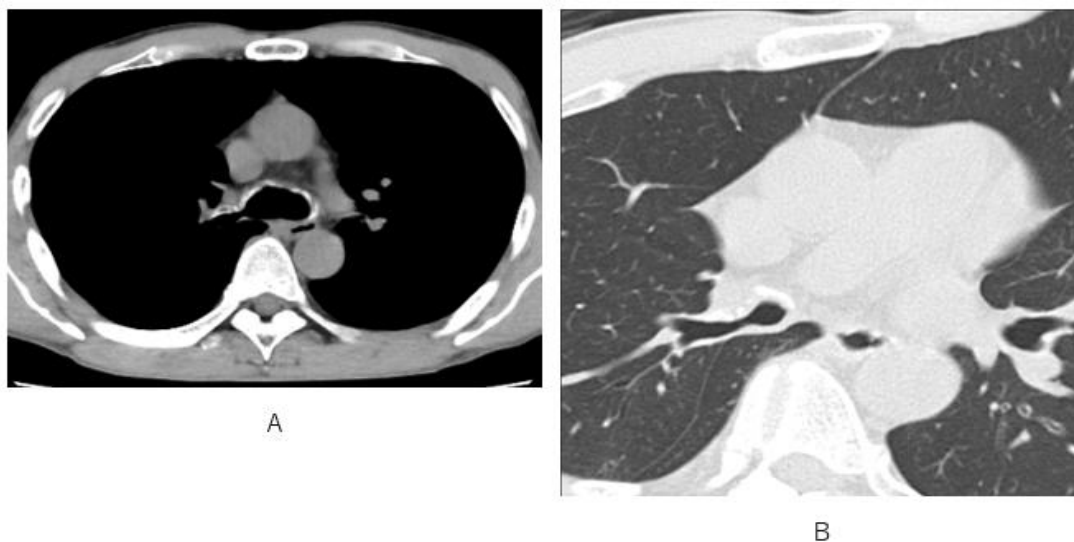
Stenotic right main bronchus with calcified cartilage at anterior bronchus wall is depicted on CT with mediastinal level (A) and pulmonary level (B).
